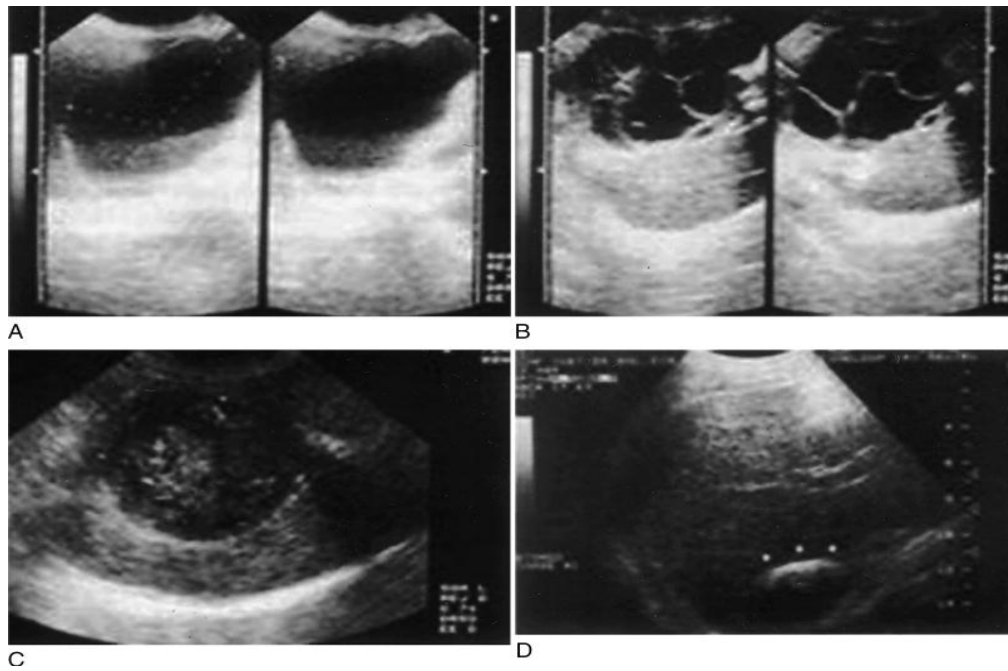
Ultrasound demonstrating typical characteristics of hydatid cyst at varying stages. A, Simple hydatid cyst with "hydatid sand." B, Daughter and granddaughter cysts and typical rosette appearance. C, Hydatid cyst filled with amorphous mass giving a solid or semi-solid appearance. D, Calcified cyst with "eggshell" appearance.
